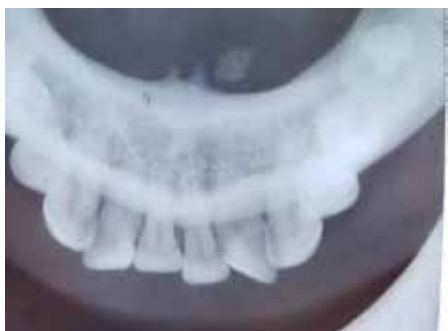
Case 1: A lower occlusal radiograph showed a nodular radio-opacity at the left lingual aspect of anterior mandible.
